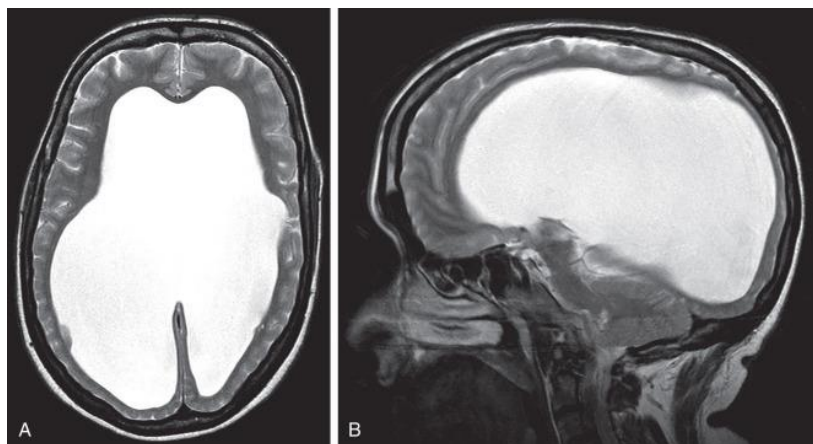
An image showing a patient with LOVA. (A) Axial T2 and (B) sagittal MRI scan of a patient with LOVA (Toma, 2000). Copyright 2018 by Elsevier.
